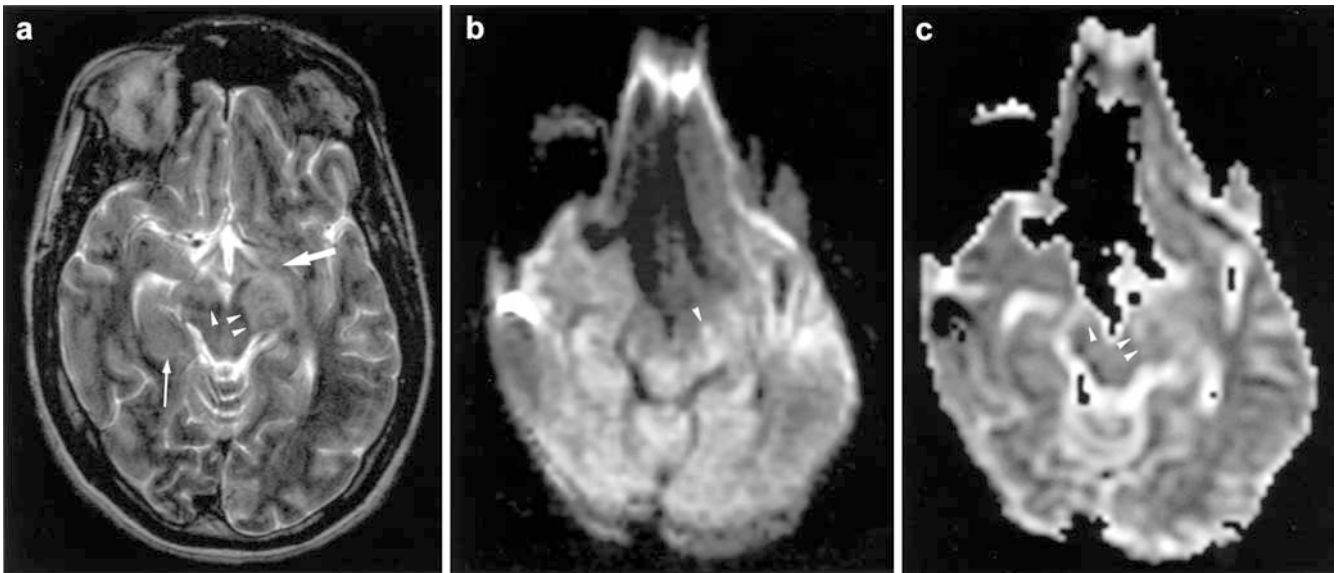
The initial presentation. a Initial T2-weighted fast spin echo magnetic resonance (MR) image (TR/TE/NEX, 5400/105/2) shows a hyperintense lesion in the midbrain (*arrowheads*) extending bilaterally into the temporal lobes (*arrows*) with prominent enlargement of the left cerebral peduncle. b On the diffusion-weighted image (TR/TE/NEX, 10000/125/1; $b=1000$), the left cerebral peduncle (*arrowhead*) is slightly hyperintense. c The apparent diffusion coefficient (ADC) values of the lesions (*arrowheads*) are slightly increased ($0.91 \times 10^{-3} \text{ mm}^2/\text{s}$ in the right and $0.98 \times 10^{-3} \text{ mm}^2/\text{s}$ in the left cerebral peduncle), suggesting vasogenic edema
